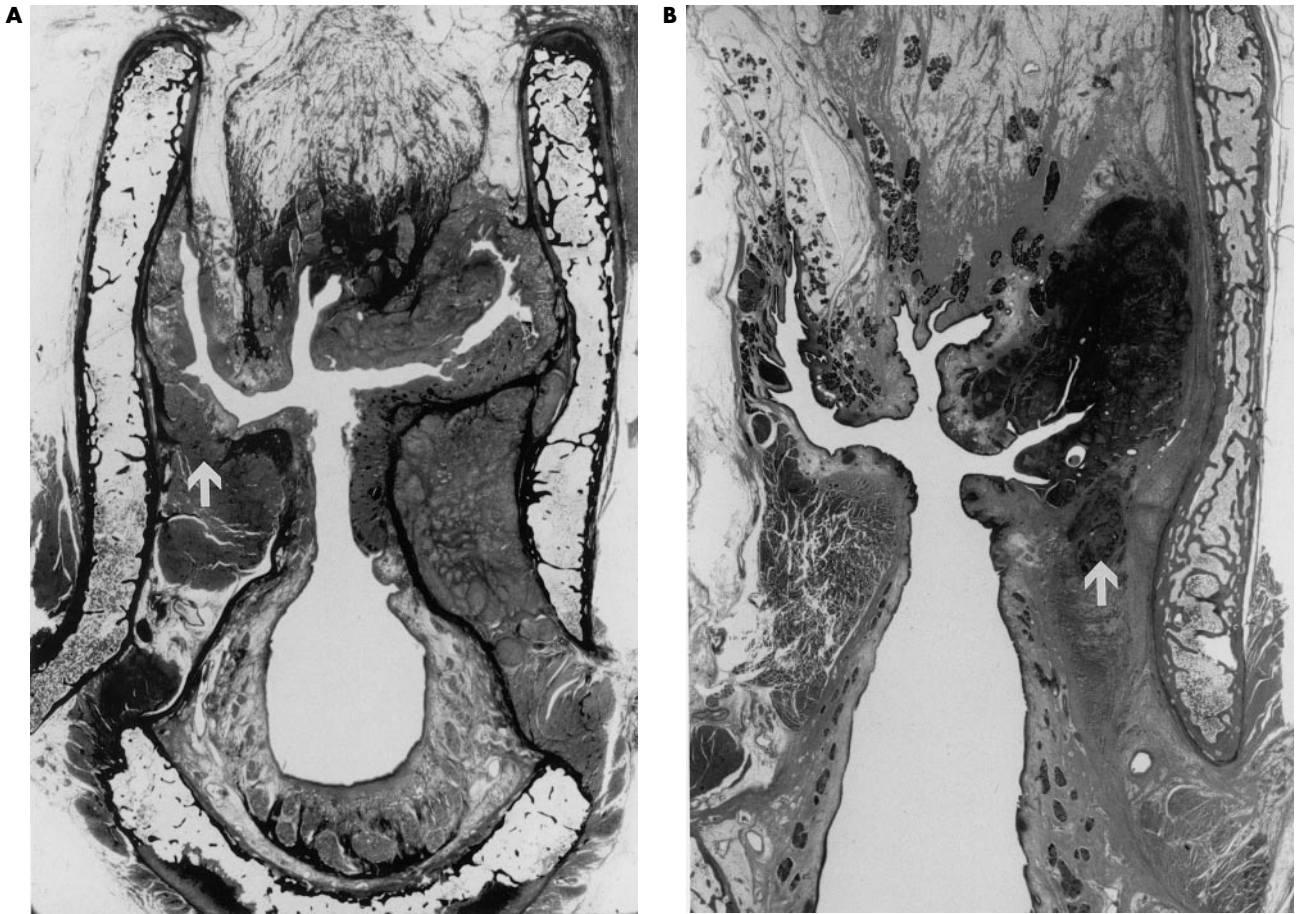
Coronal section of the larynx, demonstrating the internal cavity and its subdivisions. Note the valve-like nature of the true and false vocal folds. Reproduced with permission from Cooper MH. *Anatomy of the larynx*. In: Blitzer A, Brin MF, Sasaki CT, et al, editors. *Neurologic disorders of the larynx*. New York: Thieme Medical Publishers; 1992.
